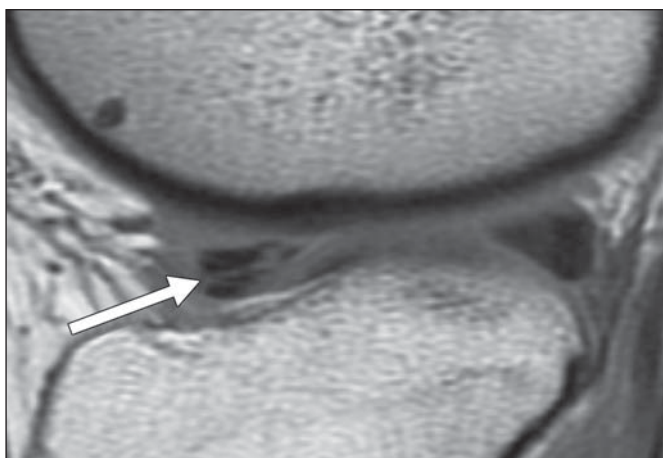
28-year-old woman with normal lateral meniscus. Midline sagittal proton density-weighted MR image shows transverse meniscal ligament (*arrowhead*) and normal fissured anterior root (*arrow*).
